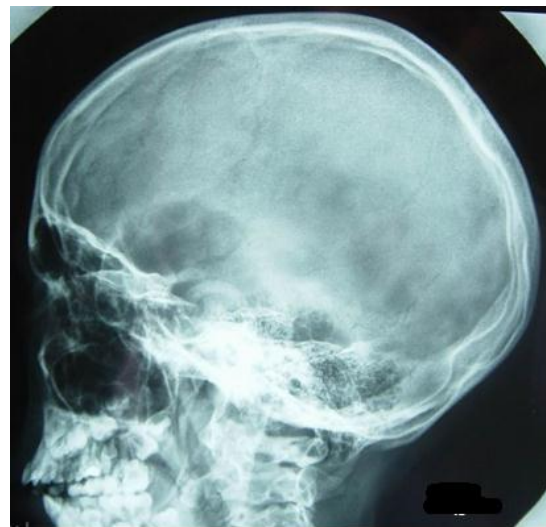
A-13-years-old-girl with was diagnosed with ADHD, presented with osteomyelitis of the calcaneus. Clinical and radiographic phenotypic characterizations and genotype were consistent with the diagnosis of MPS-type III-B (Sanfilipo syndrome)- mutation of the *NAGLU* gene located on chromosome 17q21.1) with deficiency of alpha-N-acetylglucosaminidase).
